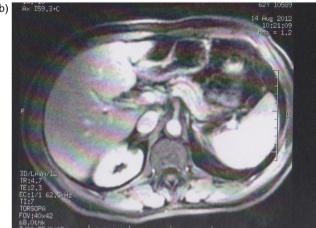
Transverse (a) nonenhanced T2-weighted and (b) arterial phase contrastenhanced T1-weighted MR images failed to expose the mass.
